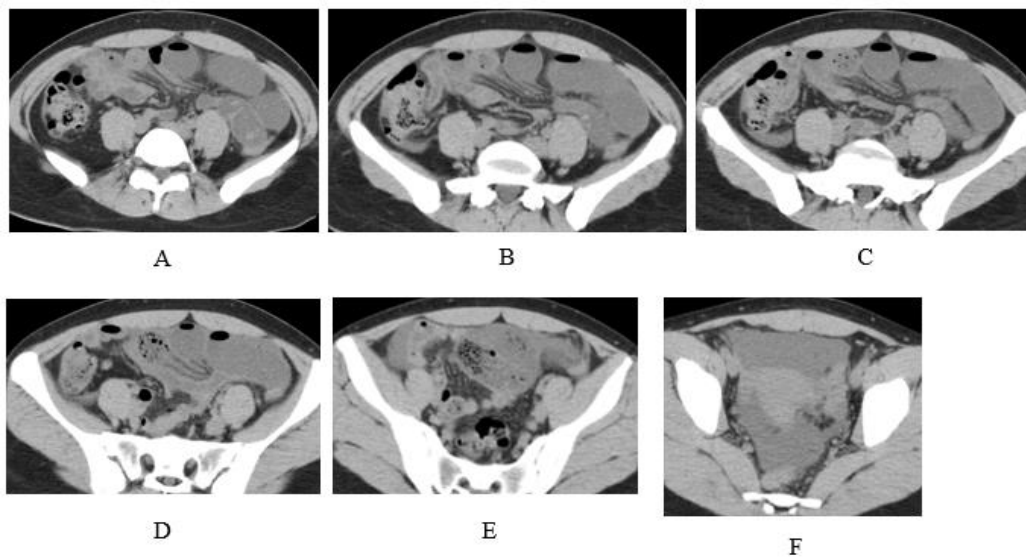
Small bowel dilatation is depicted on abdomen CT (A-E). Mural-thickened small bowel (A-C) with feces sign (B-E) is present, associated with mesentery edema (D) and ascites (F).
